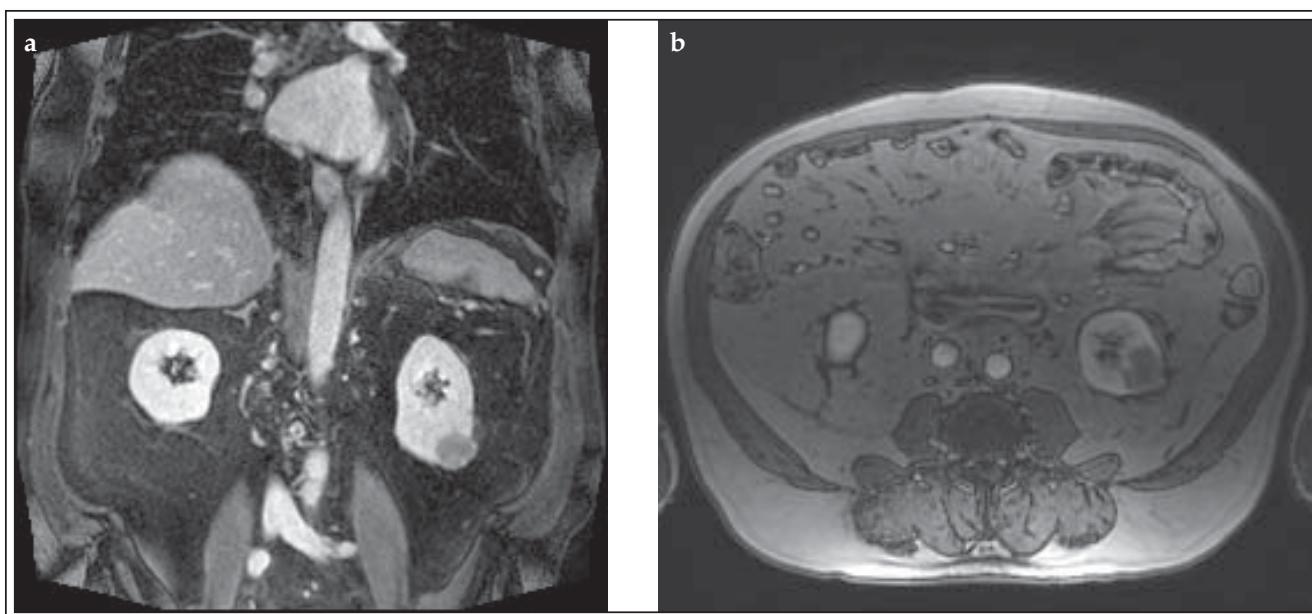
Contrast enhanced MRI of abdomen showing a heterogeneously enhancing, exophytic mass in the inferior pole of his left kidney: (a) coronal image; (b) cross-sectional image.
